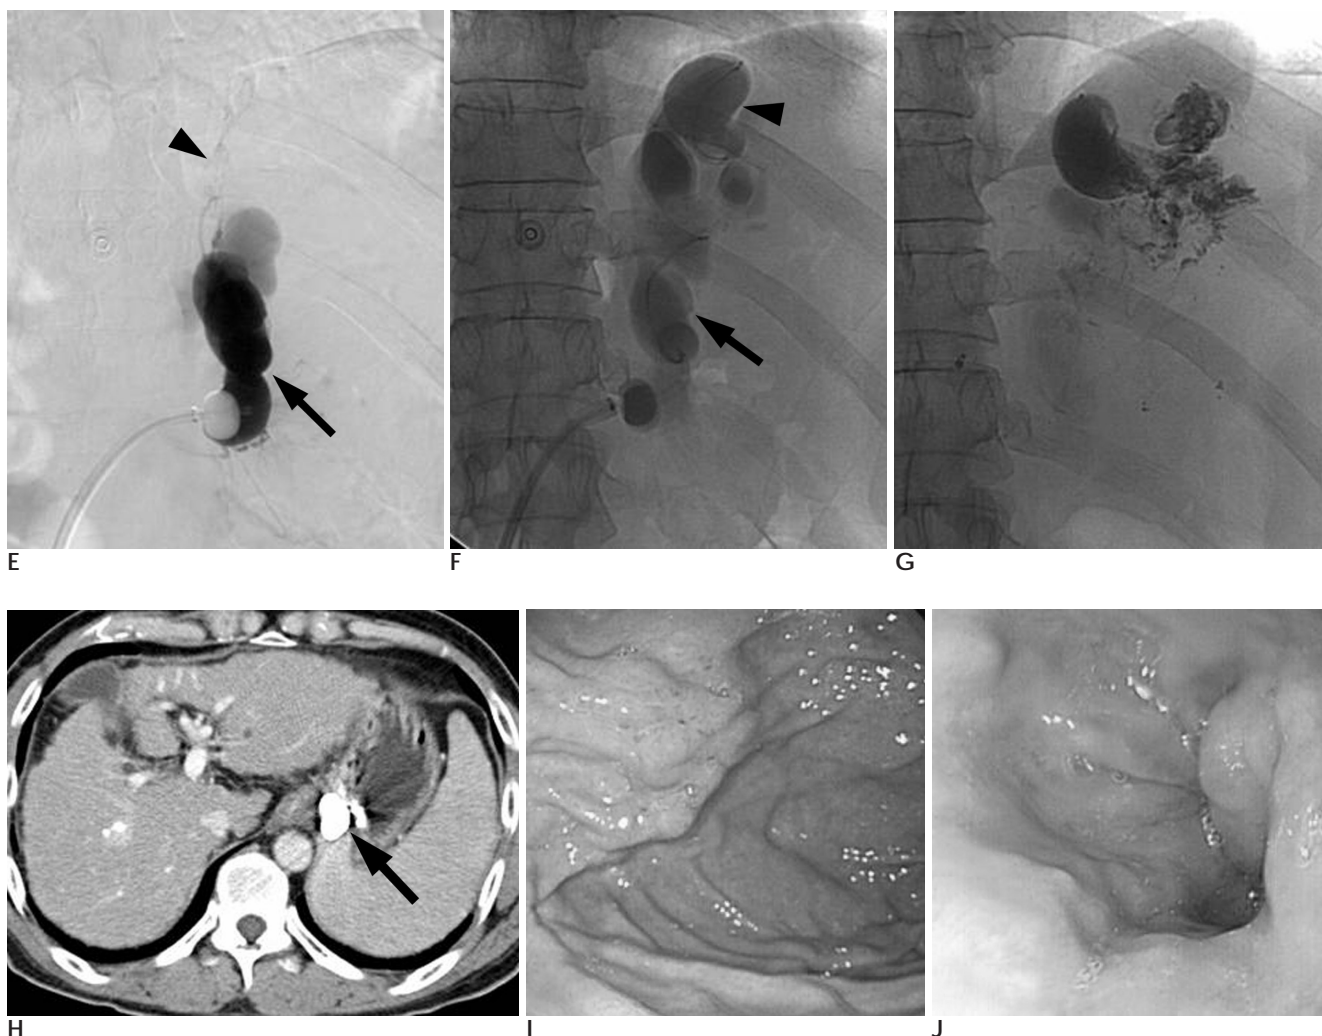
E. Balloon-occluded left renal venogram demonstrates gastroduodenal shunt (arrow) and fine collaterals (arrowhead). F. After sclerotherapy of collaterals, angiogram in gastric varices using a microcatheter shows large gastric varices (arrowhead) and gastroduodenal shunt (arrow). G. Immediate follow-up angiogram after the injection of ethanolamine oleate into the varices for two hours demonstrates the gastric varices occluded. H. Follow-up enhanced CT scan obtained 6 months after the procedure shows occluded gastric varices by clot formation (arrow). I, J. Follow-up endoscopy 6 months after the procedure shows marked improvement of gastric fundal varices, but esophageal varices had developed.
